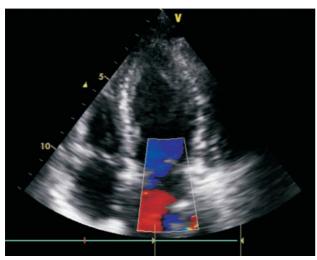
Echocardiography of the patient.
